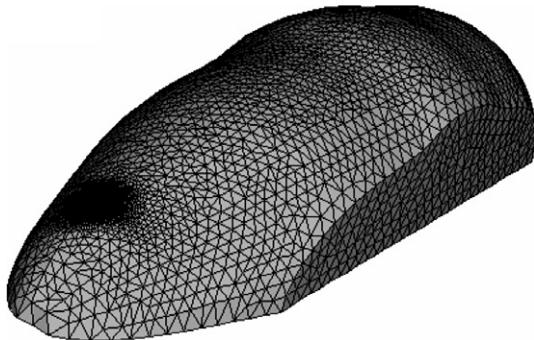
Realistic 3D ABAQUS model generated from X-ray and physical measurement. The mesh is refined in the needle puncture site and the bead locations.
